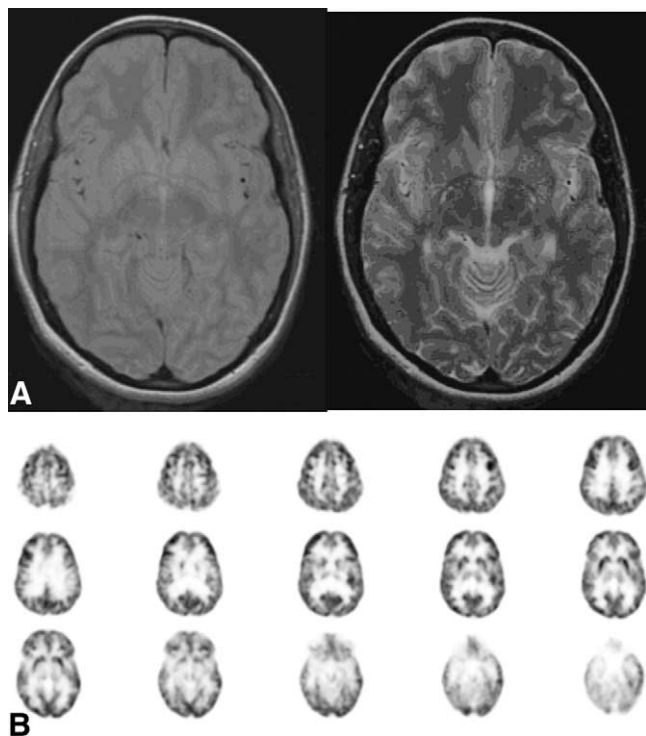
Complex partial seizure disorder: A 16-year-old girl presenting with a history of medically intractable partial complex seizures. Initial evaluation for possible surgical treatment consisted of magnetic resonance imaging (A) and EEG examination. Both of these studies were inconclusive for seizure foci. An interictal positron emission tomography with 2-deoxy-fluoroglucose study (B) showed decreased glucose metabolism in the left posterior parietal region that was subsequently confirmed to be a seizure focus.
